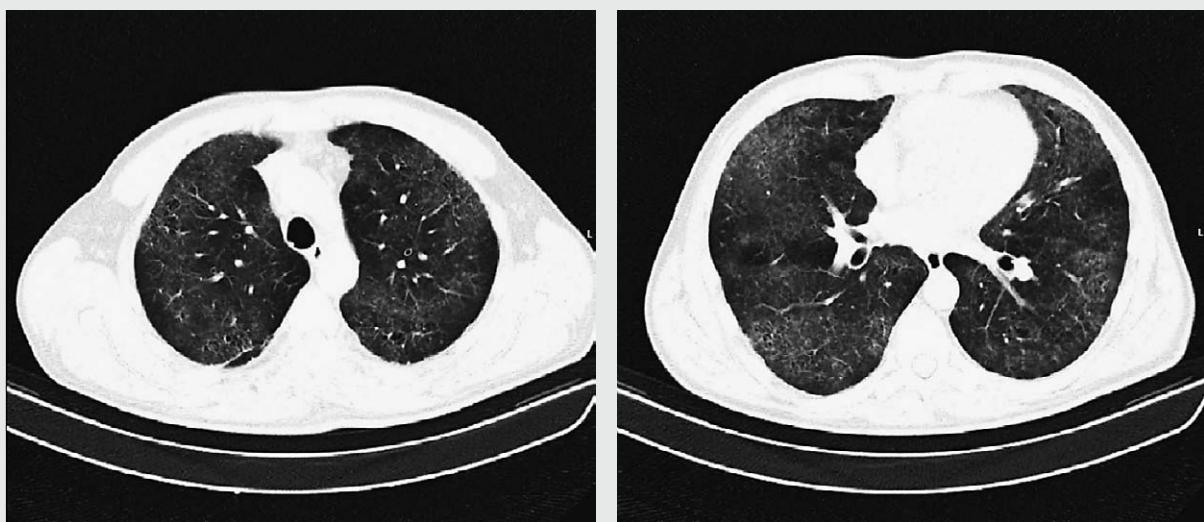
Radiography of the heart / lungs – interstitial pattern of the reticulonodular type
